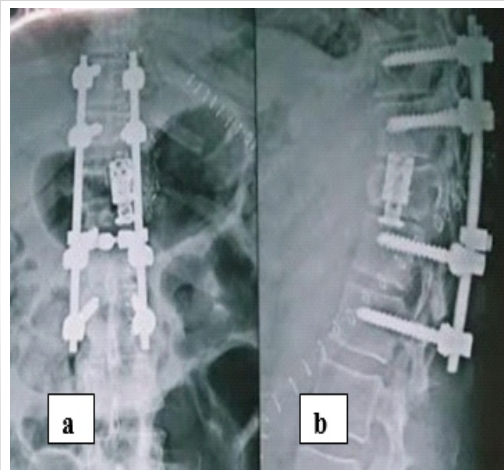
(a and b) Postoperative anteroposterior and lateral X-ray.
